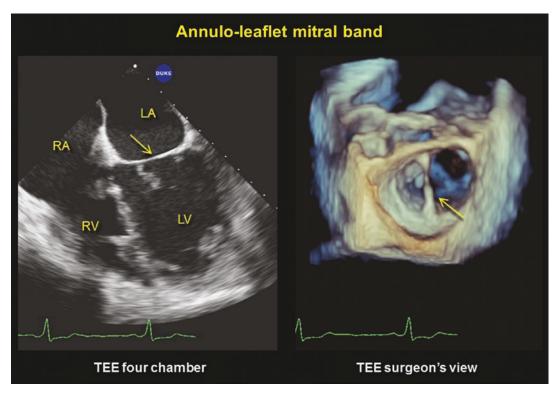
An annulo-leaflet mitral band is seen by transesophageal echocardiography (left panel). These bands go from a leaflet to the annulus. The same patient
